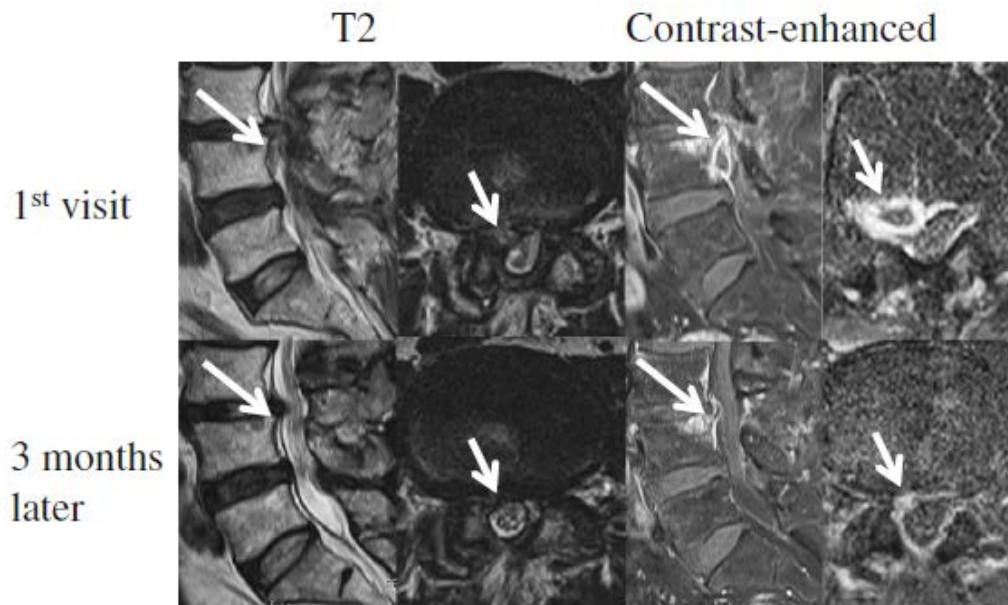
Sequential magnetic resonance imaging of a 66-year-old man demonstrating resorption of the herniated disc. from, Haro, H. (2014). current status of diagnosis and treatment. *Journal of Orthopaedic Science*, 19(4), 515-520. Reproduced without modification, under a Creative Commons Attribution-NonCommercial-No Derivatives License (CC BY NC ND). <https://creativecommons.org/licenses/by-nc-nd/4.0/>
